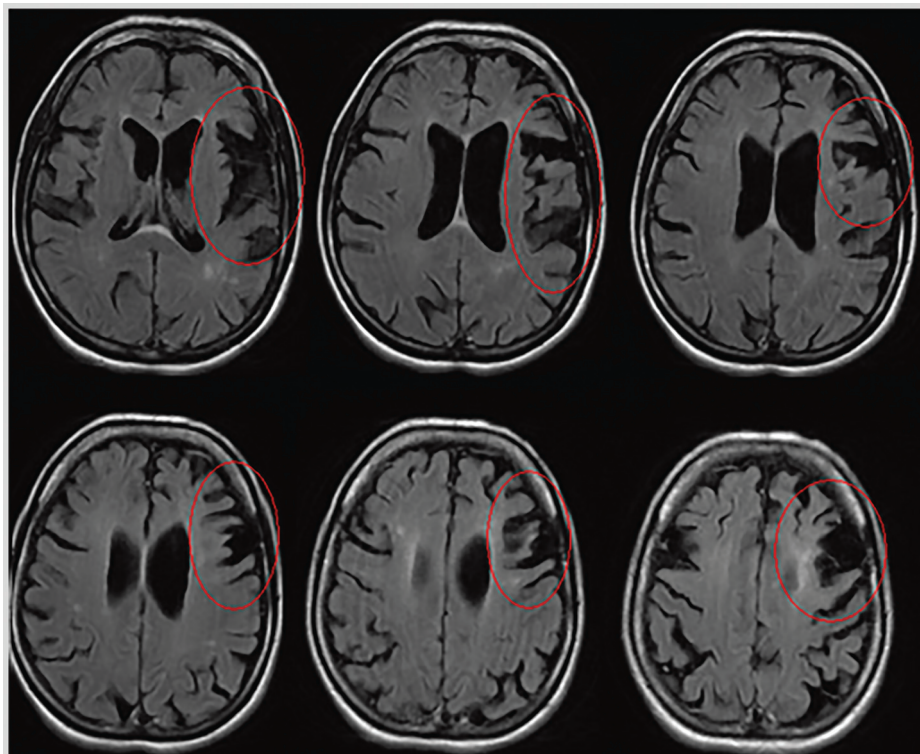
Imaging of the patient in Case 5-3 who presented with nonfluent agrammatic variant primary progressive aphasia. Axial fluid-attenuated inversion recovery (FLAIR) MRI demonstrating left posterior frontal and frontoinsula atrophy (circled in red).
